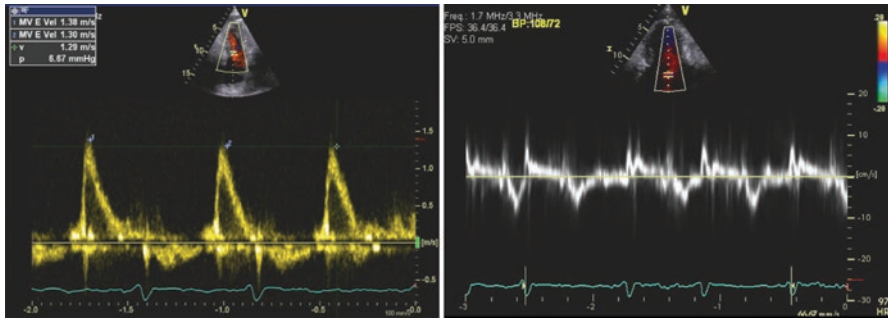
Transmitral pulsed-wave Doppler spectral tracing demonstrating *E* wave with loss of *A* wave in a patient with atrial fibrillation (left). Mitral annular tissue Doppler spectral tracing showing *E'* velocity = 0.08 m/s. *E/e'* is 16, suggestive of increased left ventricular filling pressures (right)
